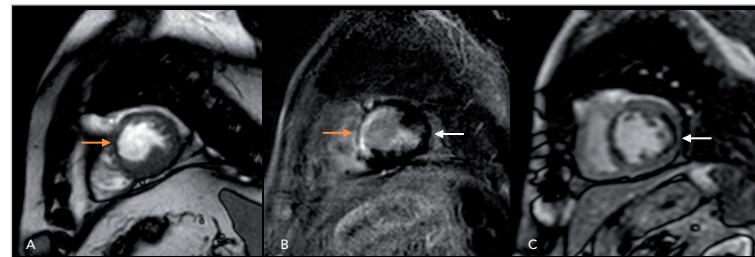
// Short axis cardiac MRI image of a patient with septal infarction and ischaemia of the lateral wall. Ischaemia is indicated by the perfusion defect of the lateral wall without delayed enhancement (white arrows B and C). The area of infarction (orange arrow) of the LV septum is diagnosed based on hypokinesia and wall thinning (asymmetrical myocardial contraction in A), subendocardial delayed enhancement (hyperintense signal, B) and perfusion defect (hypointense signal, C).
